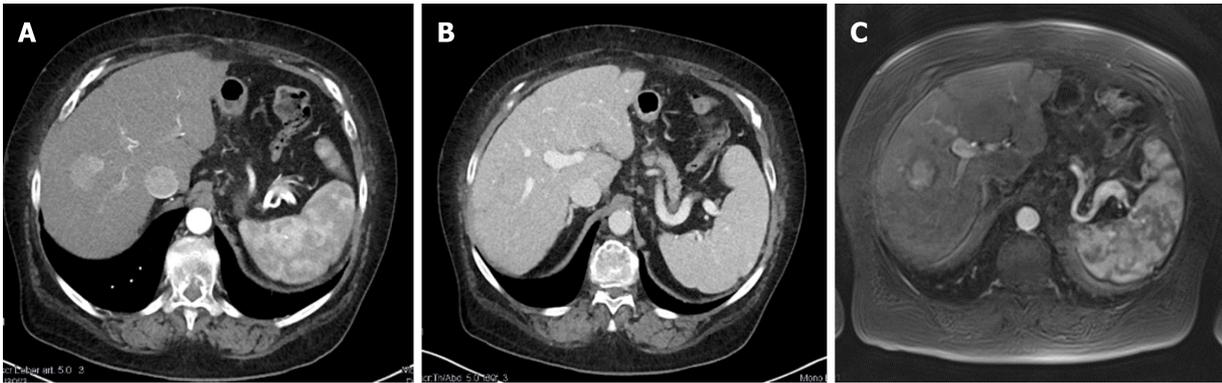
Hepatocellular carcinoma in segment VIII at diagnosis. A: Contrast-enhanced computed tomography (CT) arterial phase; B: Contrast-enhanced CT venous phase; C: Magnetic resonance imaging with liver-specific contrast agent.
